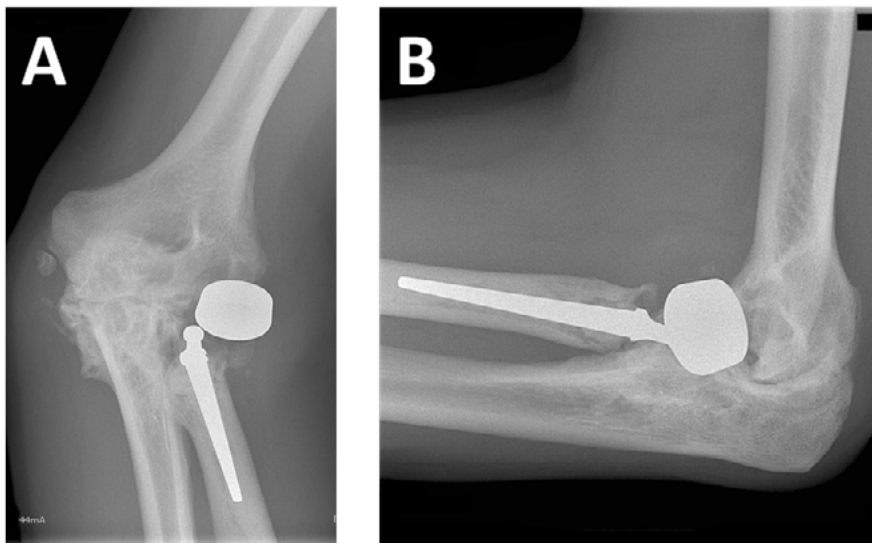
AP [A] and lateral [B] radiographs show dissociation of the prosthesis due to failure of the snap-on articulation between the head and the stem.
